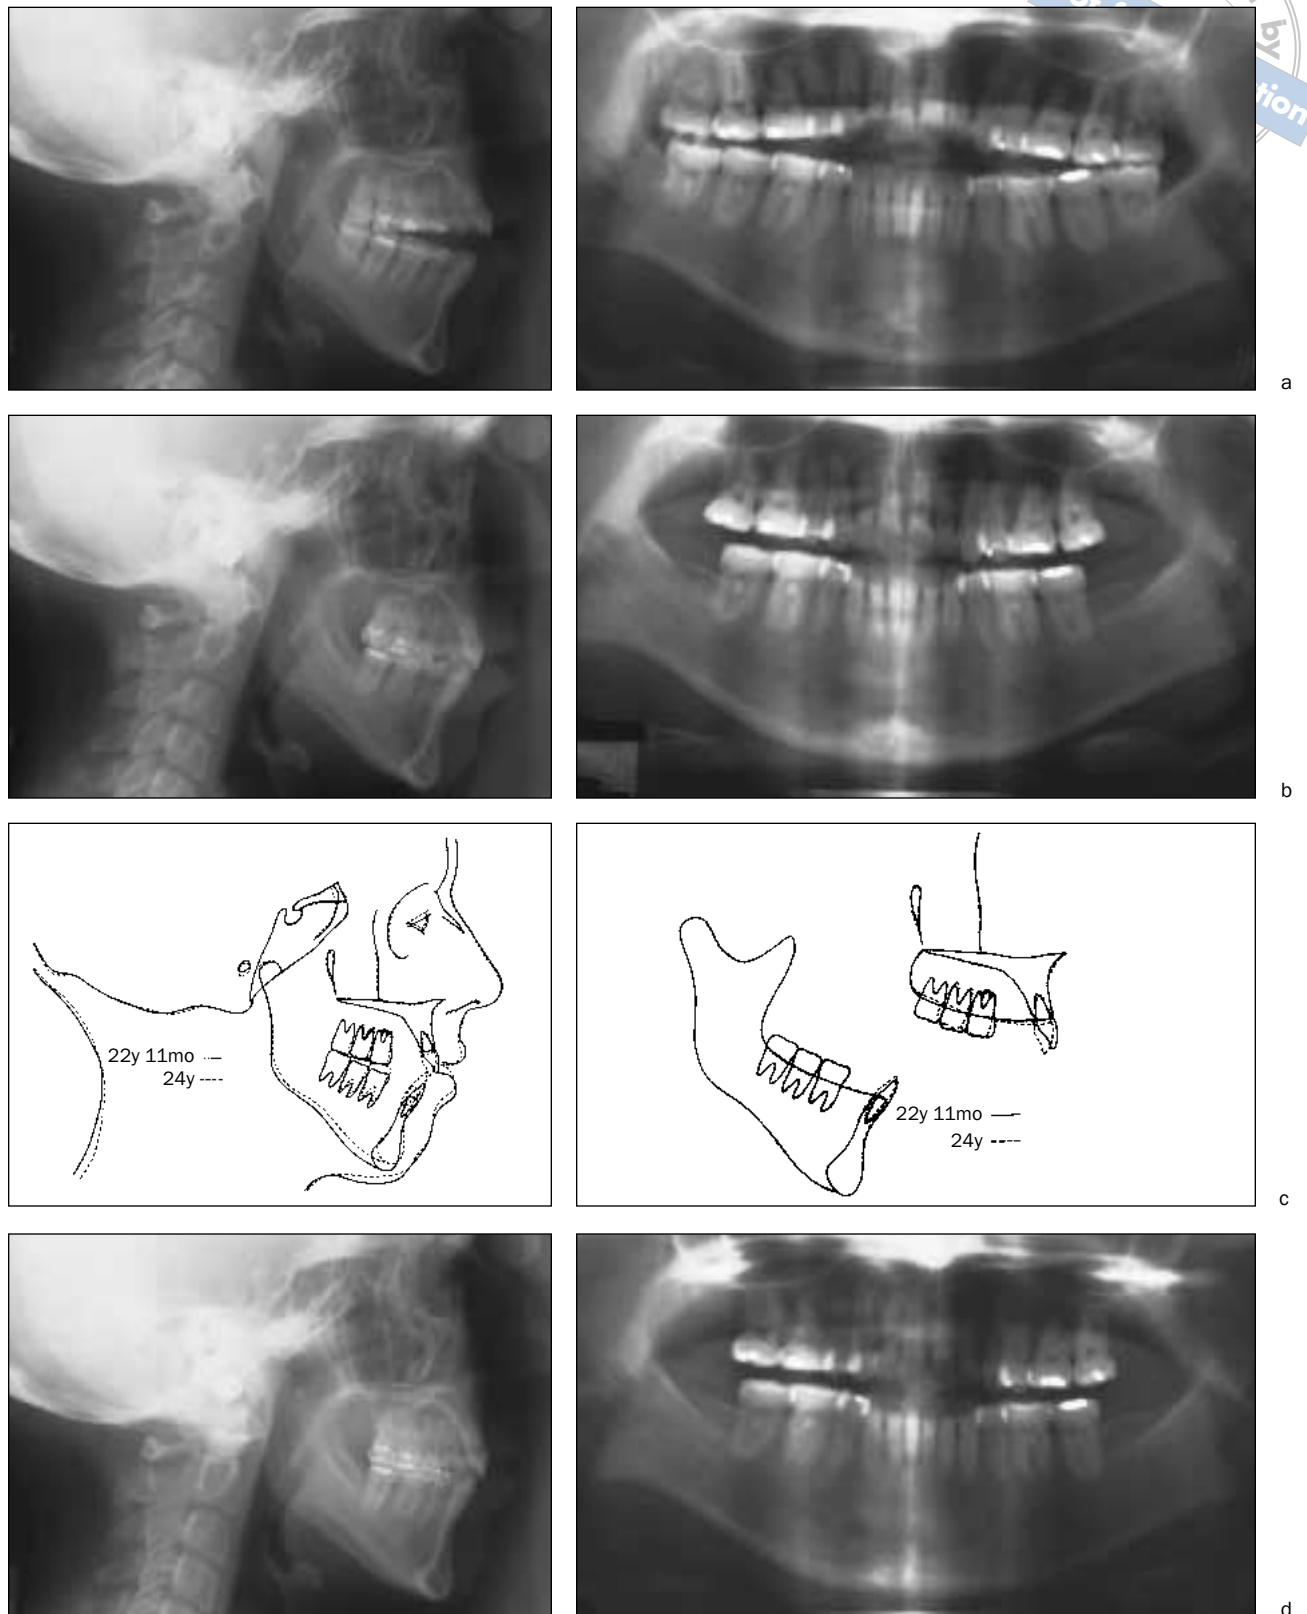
Case 1. (a) Pretreatment cephalogram and panoramic radiograph. The ODI was 69 degrees and the APDI was 79 degrees. (b) Posttreatment cephalogram and panoramic radiograph show a normal dental relationship. (c) Posttreatment cephalometric superimposition reveals that the molars were uprighted and the mandible autorotated counterclockwise about 4 degrees. (d) The 37-month follow-up cephalogram and panoramic radiograph show excellent stability.
